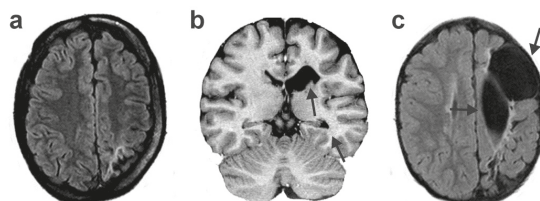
Brain MRI, sequences corresponding to lesion caused by (a) ulegyria (U), (b) porencephalic cysts (PC) and (c) both ulegyria and porencephalic cyst (U+PC).
